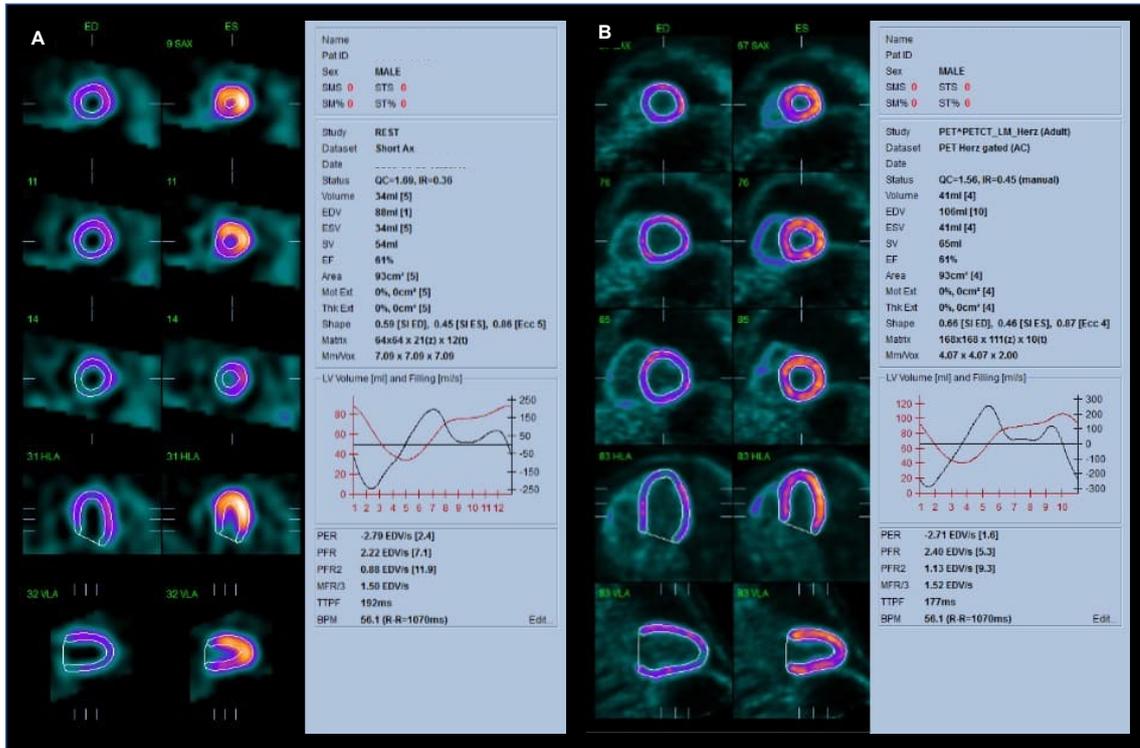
Representative images of gated MPS (A) and gated FDG PET (B). In each panel the left column shows end systole, the middle column end diastole, and the right column the left ventricular functional parameters. Note that PET detects a proportionally larger EDV and ESV as compared to SPECT, probably due to superior image resolution and reduced partial volume effects. LVEF is equal.[23]
